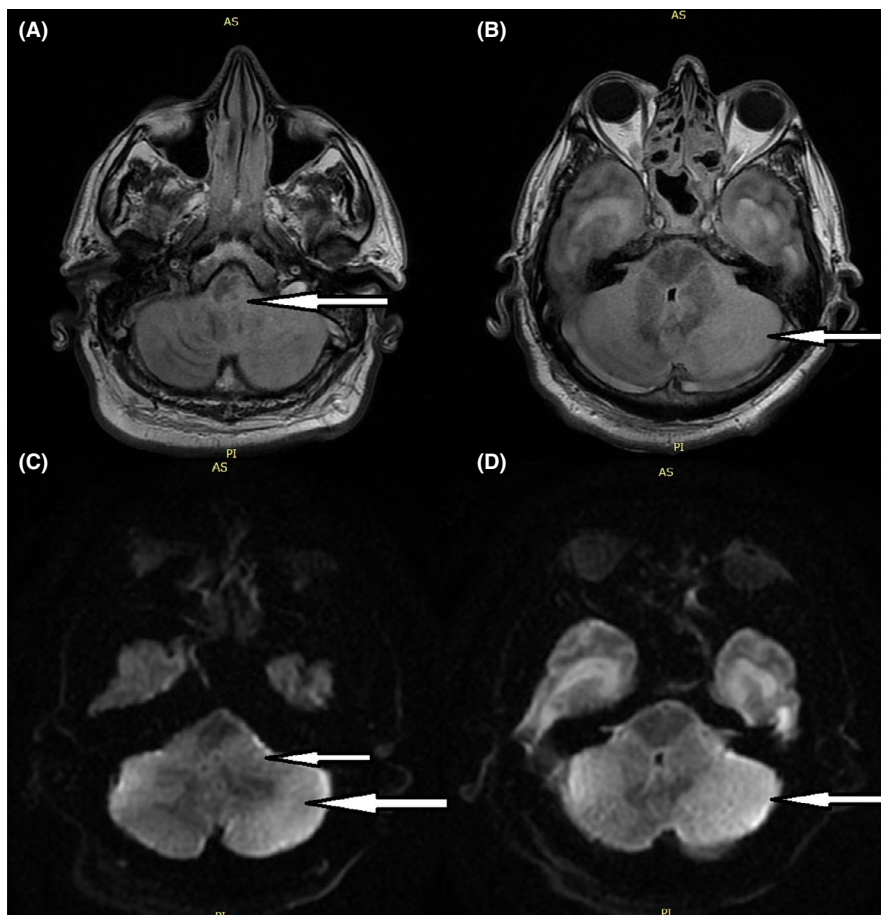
(1.5 Tesla): MRI axial fluid-attenuated inversion recovery (FLAIR) sequence (A, B) and diffusion-weighted image (DWI) sequence (C, D) showing bilateral, asymmetric, hyperintensity in the cerebellum with extension into the brainstem (A, C)
